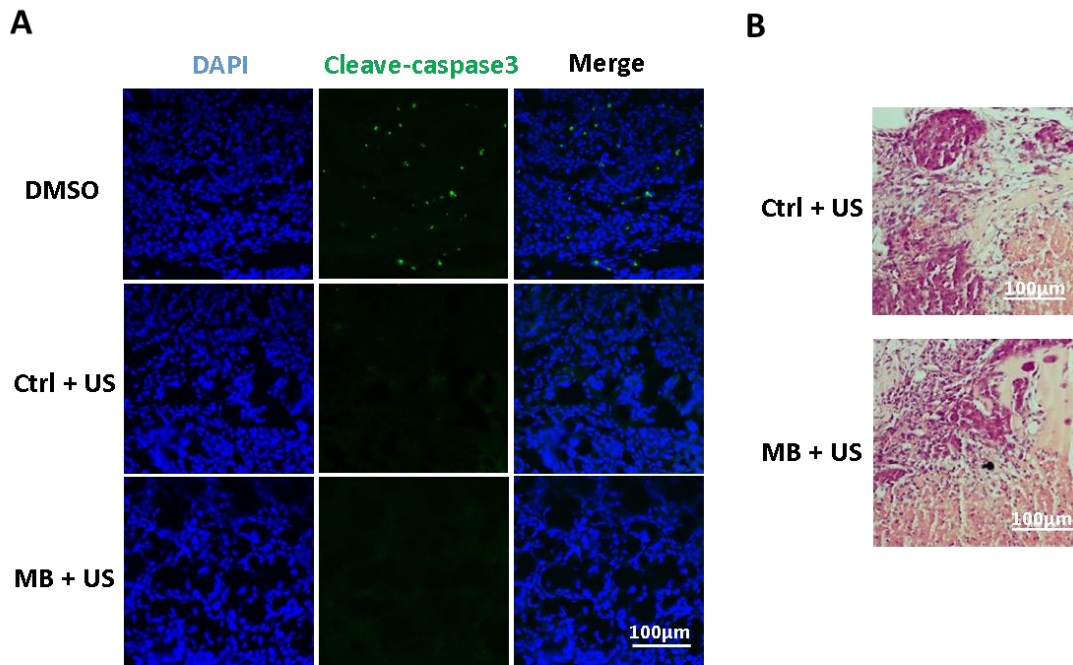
Biosafety assessment of microbubble-enhanced ultrasound stimulation *in vitro*.
